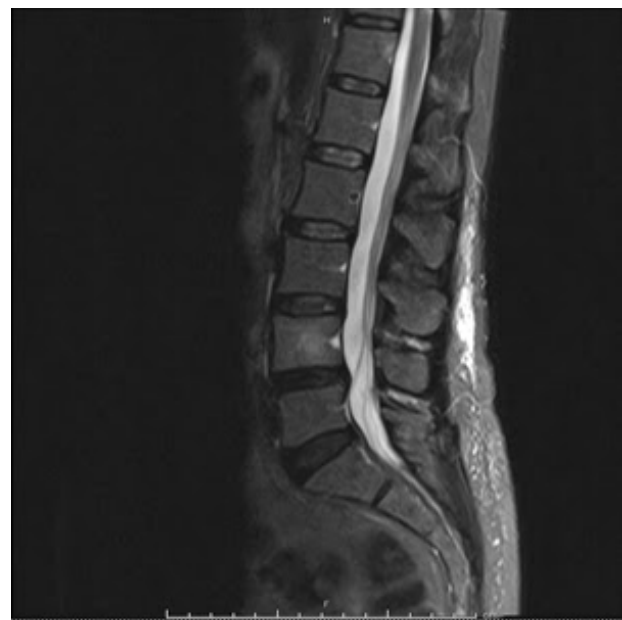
MRI of lumbar and sacral spine without pathologic fractures or spinal cord compression.
